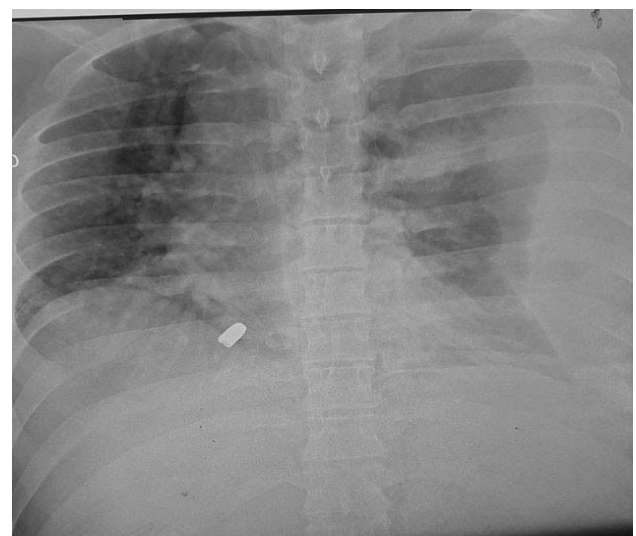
Chest ribs fracture X-ray of domestic violence victims
